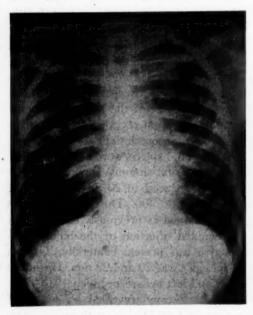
(Schultz). Roentgenogram of the chest, showing enlarged hilar shadows and radicular infiltrations throughout both lungs.
